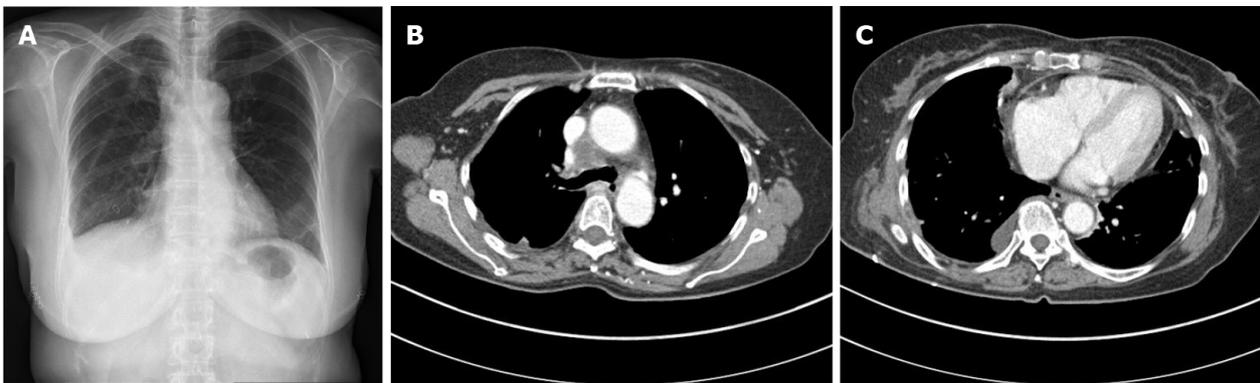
Chest X-ray radiograph and computed tomography. A: Chest X-ray radiograph findings improved after removal of the chest tube and drainage catheter; B and C: Chest computed tomography demonstrated (B) a decrease in size of the right paratracheal lymph node and (C) decreased amount of pericardial effusion and improvement in diffuse pericardial thickening.
